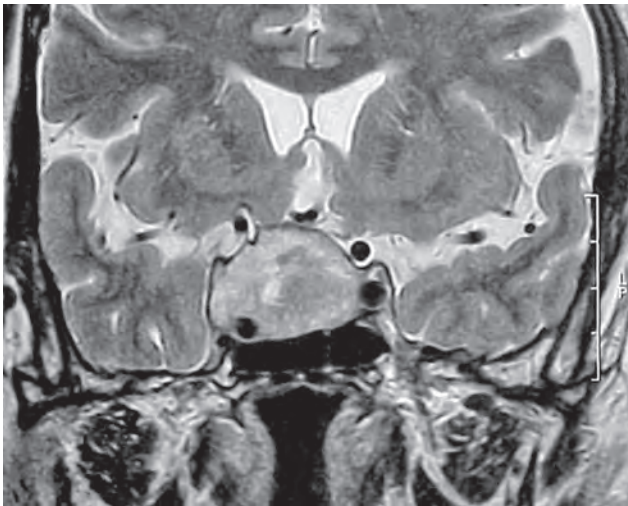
MRI T2W coronal image showing pituitary adenoma extending up to the carotid artery on the left side and on the right side the adenoma is displacing the carotid inferolaterally and extending beyond it
